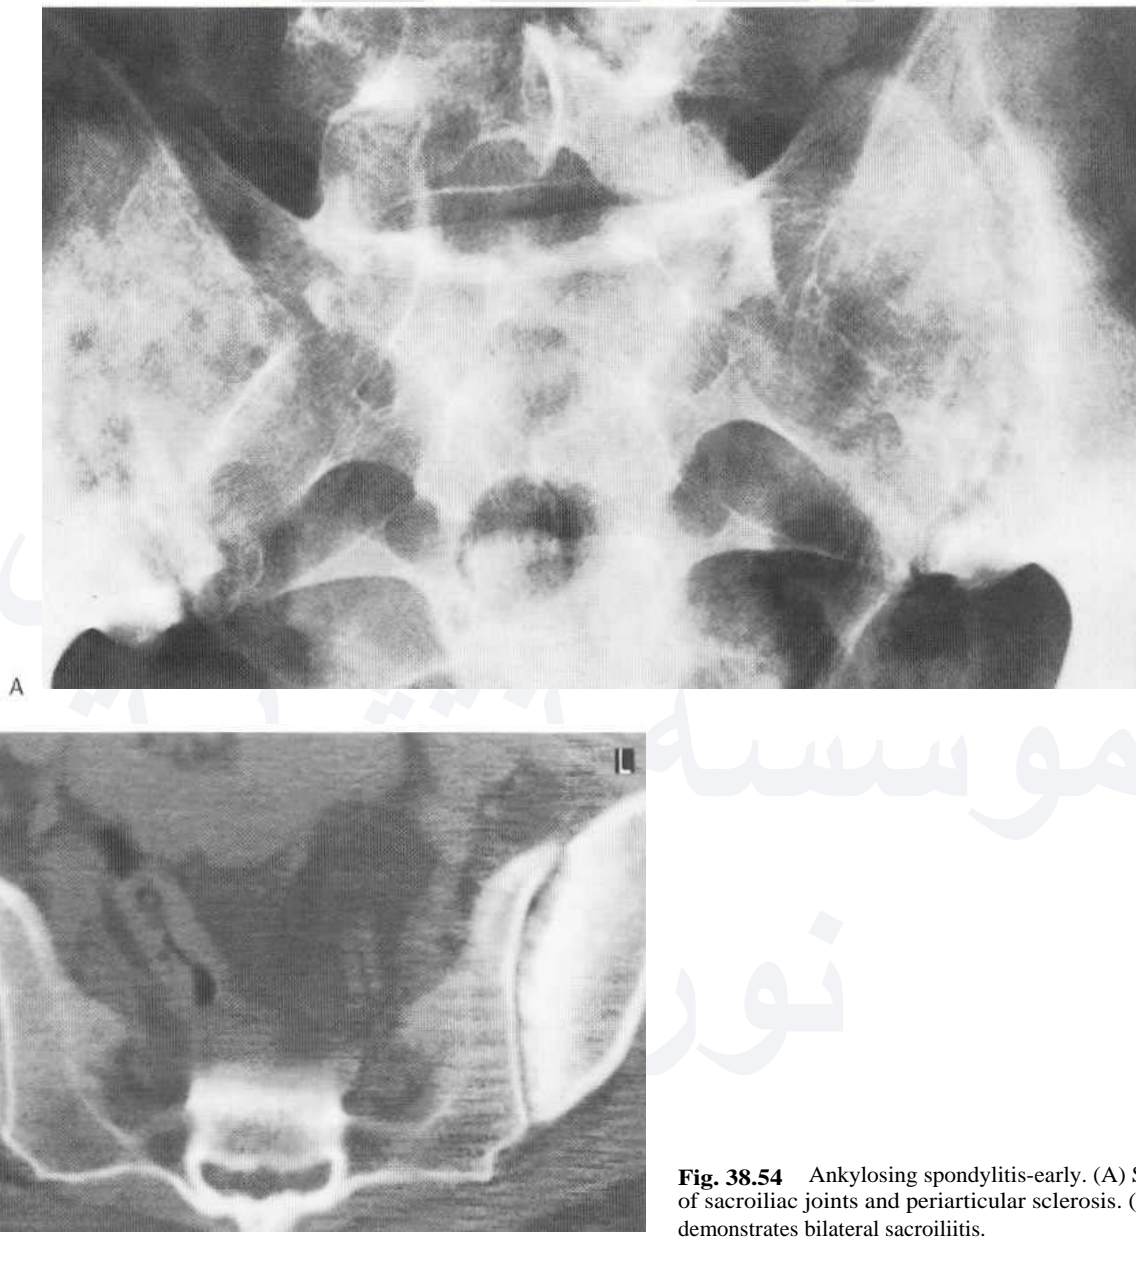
Ankylosing spondylitis-early. (A) Serrated margins of sacroiliac joints and periarticular sclerosis. (B) CT scanning demonstrates bilateral sacroiliitis.
